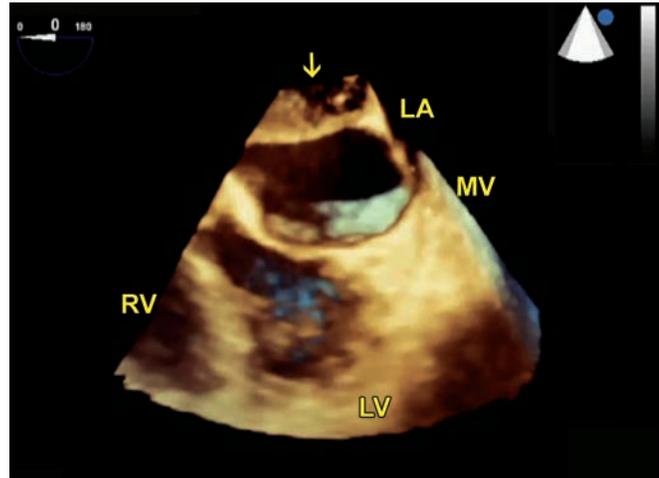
Transesophageal echocardiogram 4-chamber 3D image. Arrow points to a linear echodensity within the left atrium.
